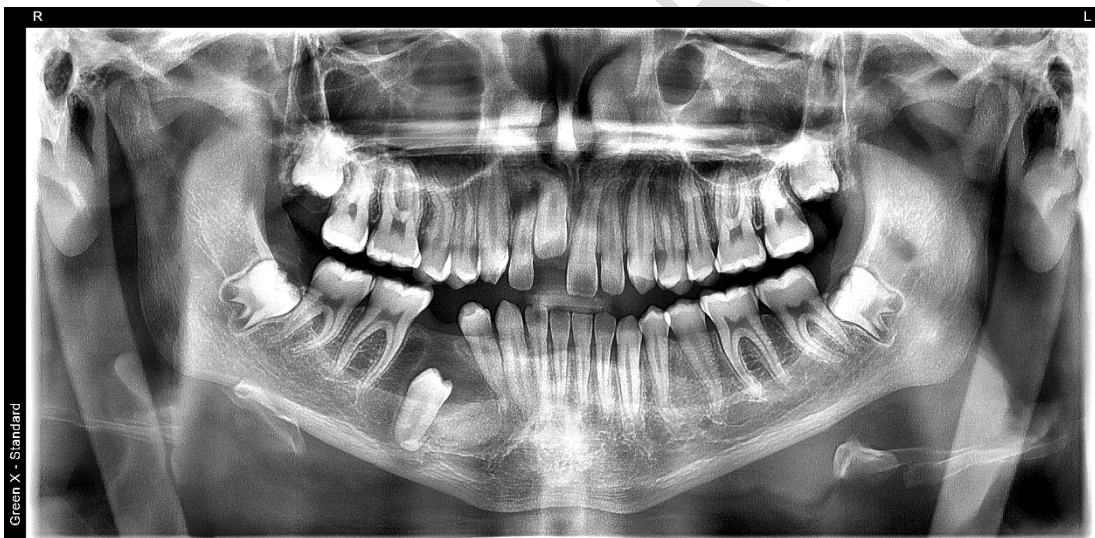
panoramic x-rays after 8 months, already with the decompression technique
